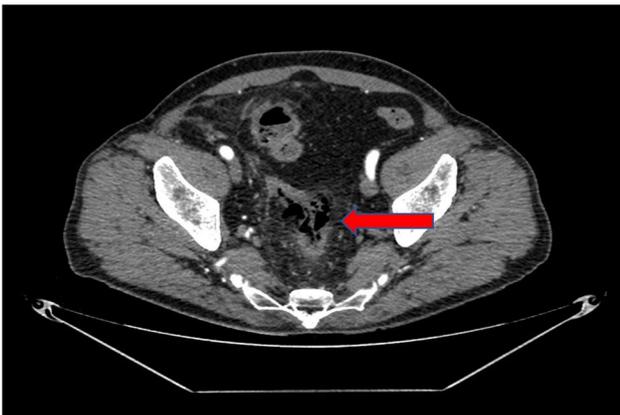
Post-procedural CT scan showing recto-sigmoid ischaemia, with pneumatosis and peri-sigmoid oedema (red arrow)
